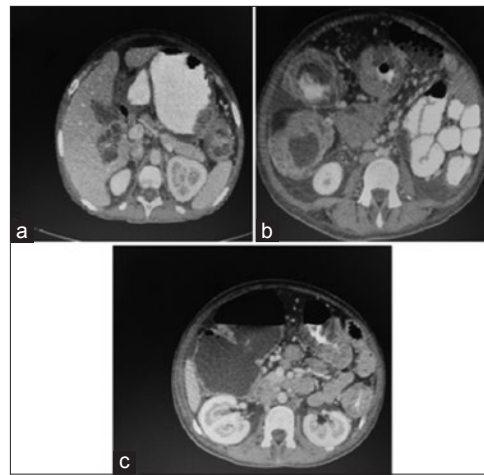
(a-c) Computed tomography scan of abdomen revealed marked wall thickening of transverse colon, and the upper two-third of the descending colon is noted, consequent marked luminal narrowing has been identified, resulting in marked dilatation of the ascending and proximal part of the transverse colon
